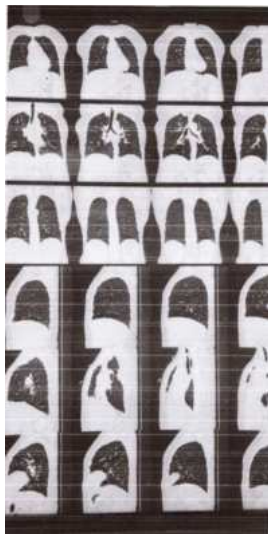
HRCT Chest (Coronal Section)
